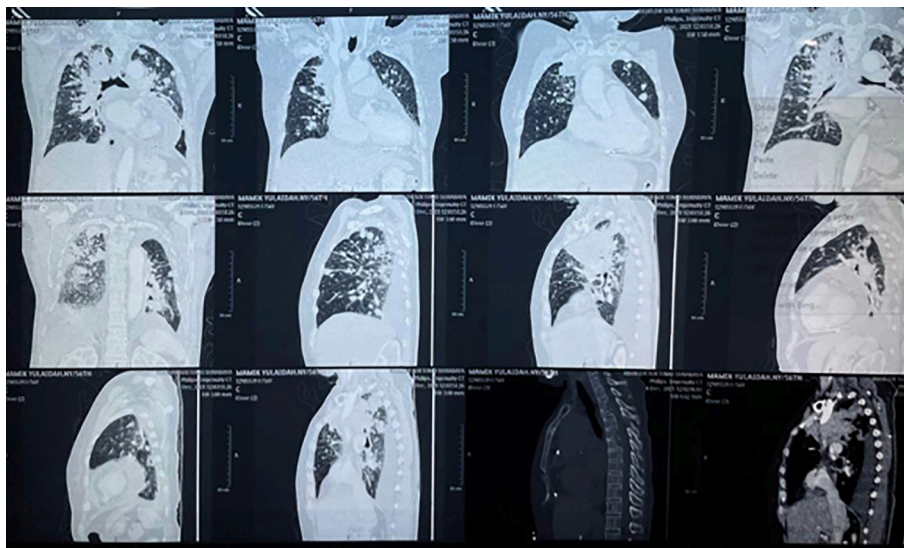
Thorax CT with contrast showed multiple nodules in both lungs, multiple lytic at sternum and vertebrae reflecting a metastatic process.
